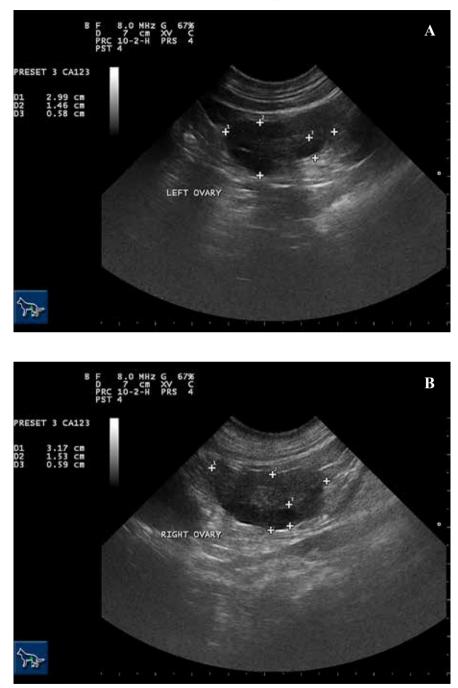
Ultrasonography of the Shar Pei's ovaries during recombinant human chorionic gonadotropin treatment. Sagittal view of both ovaries, performed by MyLab[™] 40 VET, Esaote S.p.A., Genova, Italy. A and B show ovaries on day 18 after insemination
